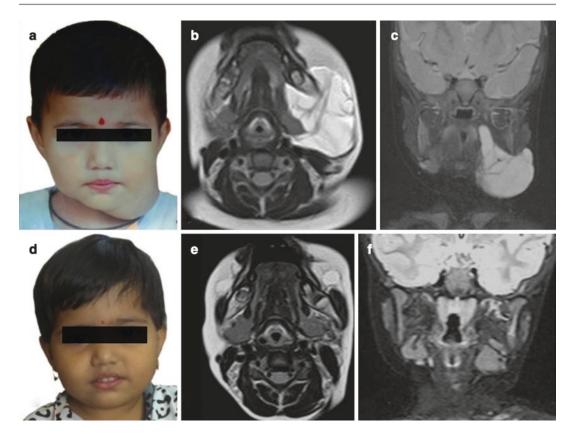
(a) Clinical photograph of the patient is showing lower cheek and angle of the mandible swelling (b, c) Axial (a) and Coronal (b) T2 weighted Images of MRI show a hyperintense, well-defined mass in left masticator space, mandibular space, para pharyngeal space and is abutting the carotid vessels. Lesion has multiple
